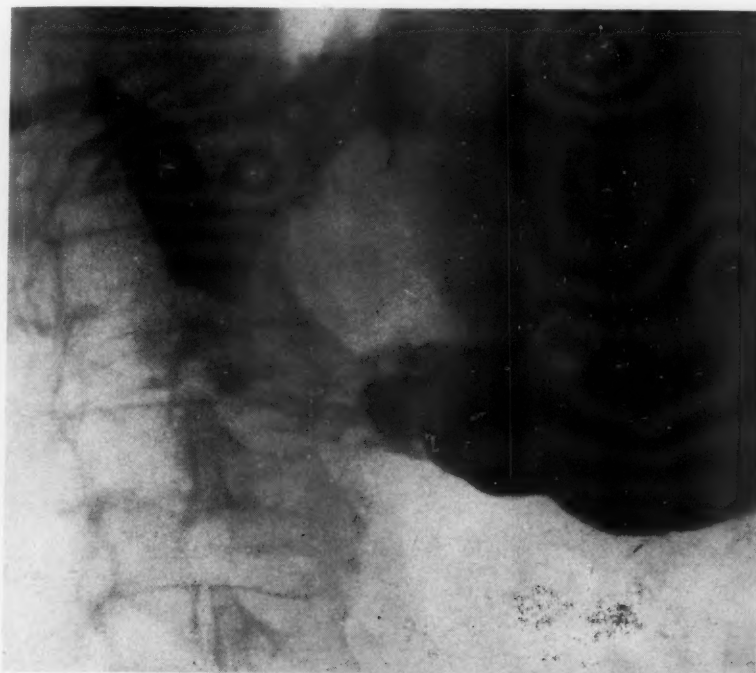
X-ray of the liver after a barium meal in a patient who had had the conventional anastomosis between the duodenum and stump of the common hepatic duct for a complete absence of the common duct. The anastomosis was performed over a rubber tube which was passed a few weeks later. Note the massive regurgitation of barium into the dilated intrahepatic ducts. He is having frequent chills and needs another type of repair.
